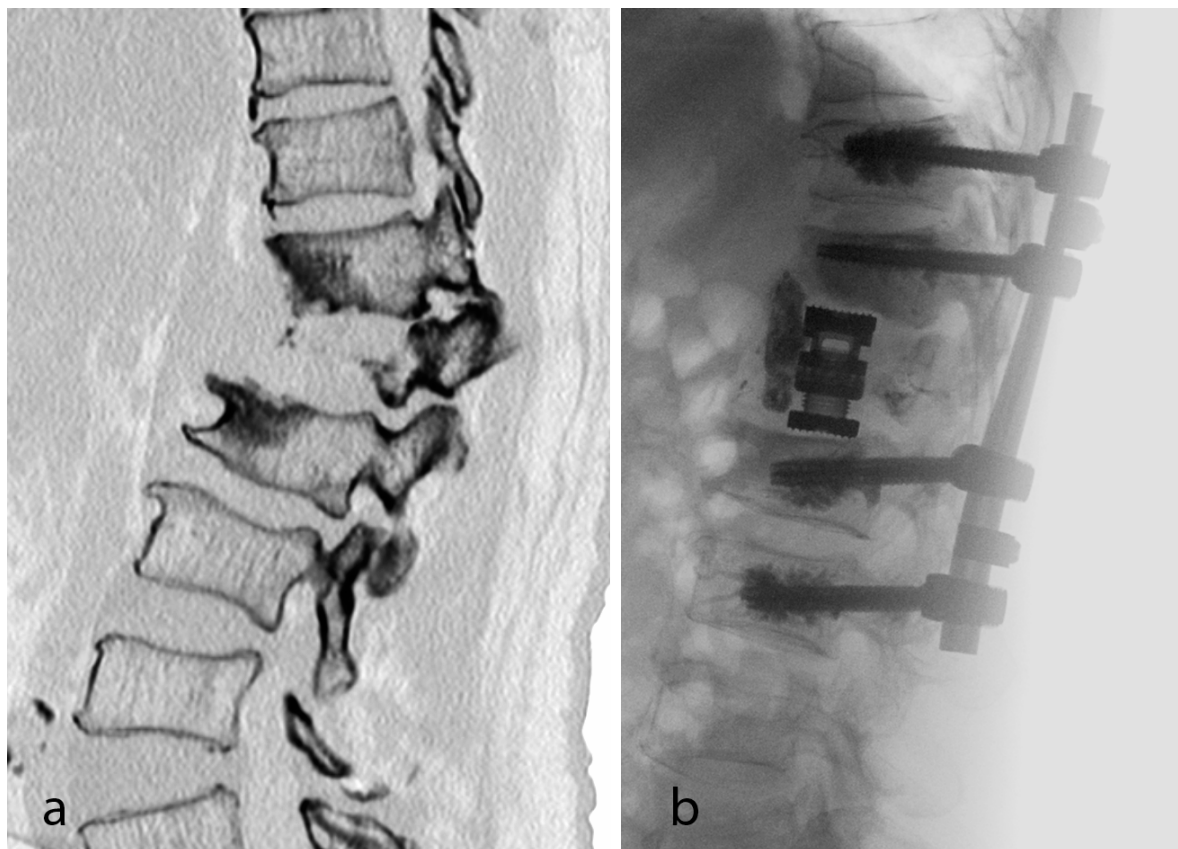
(a) Preoperative CT of a patient with vascular tumor of L1 with kyphotic deformity. (b) Postoperative radiograph after embolization, correction by anterior cage via MIS lateral approach and cement augmented percutaneous posterior spinal instrumentation.
